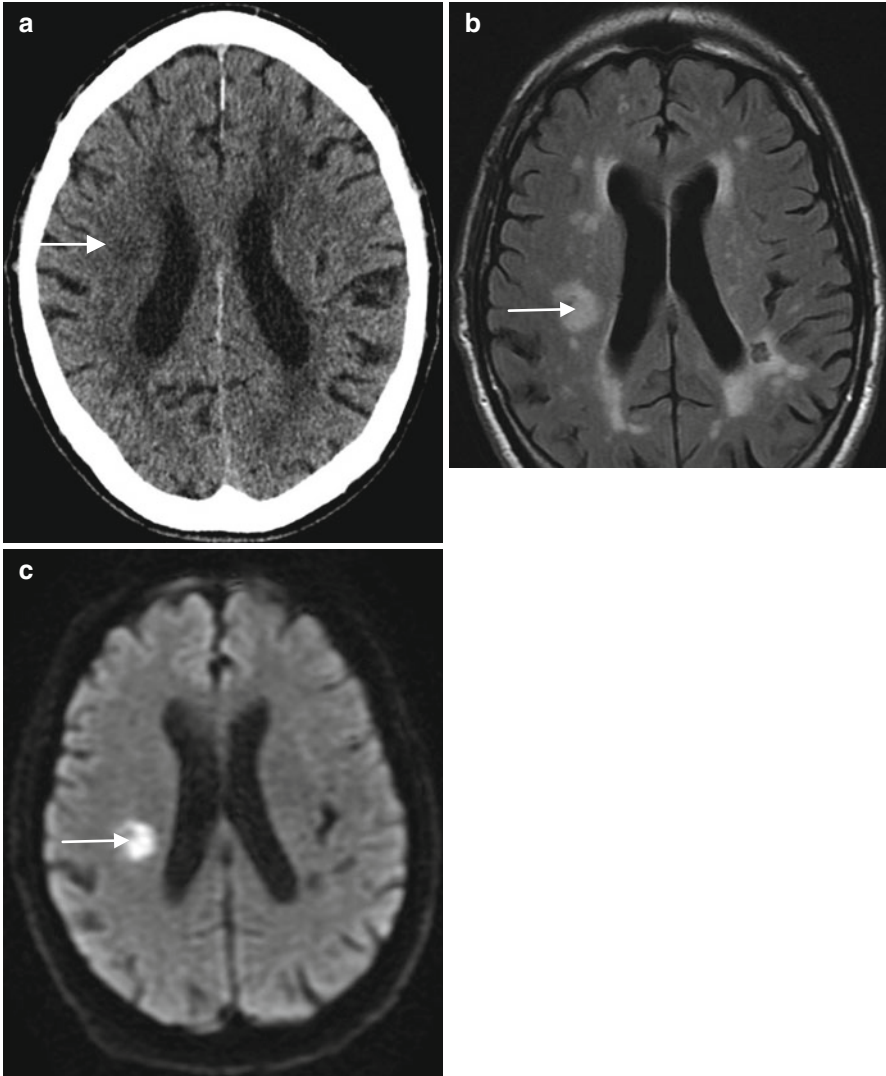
(a) Non contrast CT of the brain in a 76 year old male patient with left sided weakness demonstrates a subtle focal area of low attenuation (*arrow*) in the periventricular deep white matter of the posterior right frontal lobe on a background of chronic small vessel ischaemia. MRI was subsequently performed. (b, c) Axial T2 FLAIR (b) demonstrates an area of high signal abnormality (*arrow*) in the right cerebral hemisphere corresponding with the subtle area of abnormality visualised on CT. Note the additional areas of high signal surrounding the ventricles, thought to represent chronic deep white matter ischaemic change. Diffusion weighted imaging (c), optimised for detection of acute ischaemia, demonstrates only a single focus of marked corresponding high signal in keeping with acute infarction in this region
